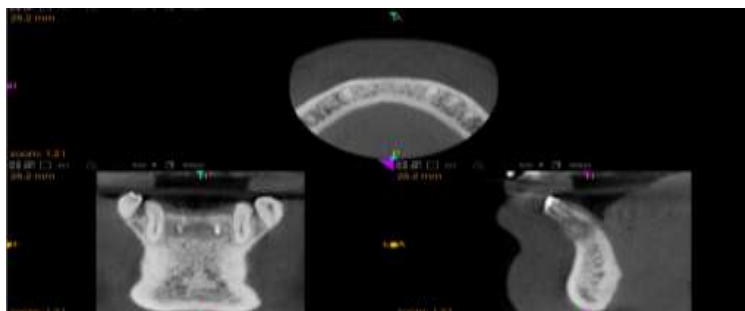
CBCT after 6 months
